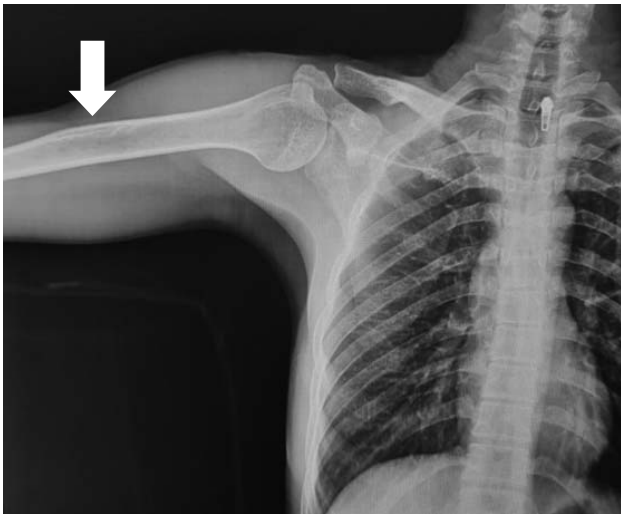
X-Ray Shoulder lateral view shows focal cortical thickening with central lucency along the lateral aspect of humerus at the deltoid insertion site.
